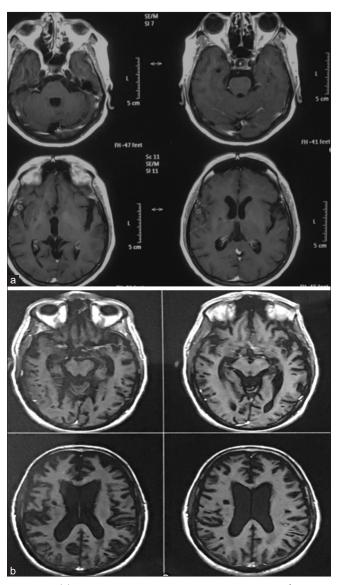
(a) Contrast magnetic resonance imaging axial section showing multiple tuberculomas with meningeal enhancement and with dilated ventricle in a 56 male with definite tuberculous meningitis Stage 3 presented on day 50 of illness, cerebrospinal fluid cells 10/mm³ with all lymphocytes, and protein 60 sugar 45. (b) At 1 month, the patient had paradoxical worsening in the form of increased hydrocephalus.
